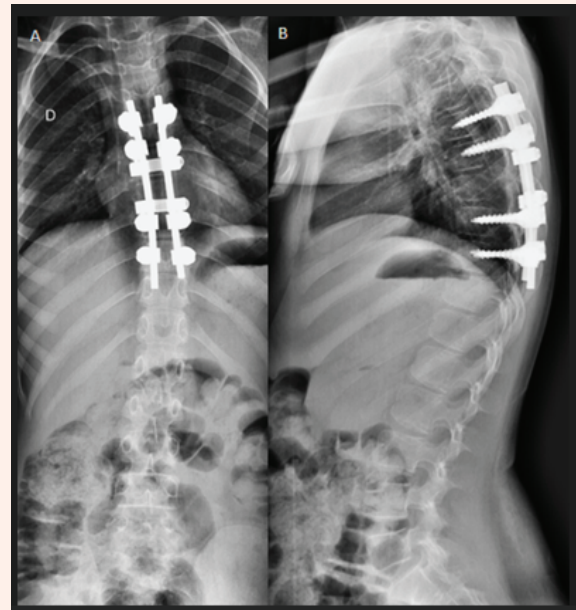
Postoperative anteroposterior (A) and lateral (B) radiographs showing adequate insertion of screws in the pedicles and vertebral bodies from T6 to T10.
